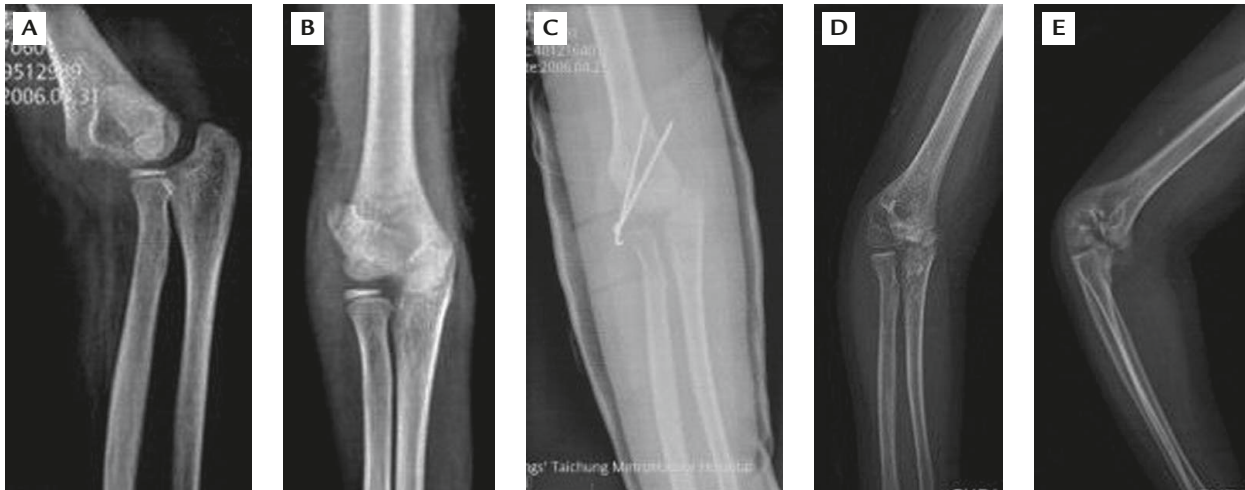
Case 3: (A, B) preoperative X-rays; (C) X-ray in cast after operation showed malreduction of the lateral condyle; (D, E) X-rays at 24 months' follow-up showed malunion and cubitus varus deformity.
